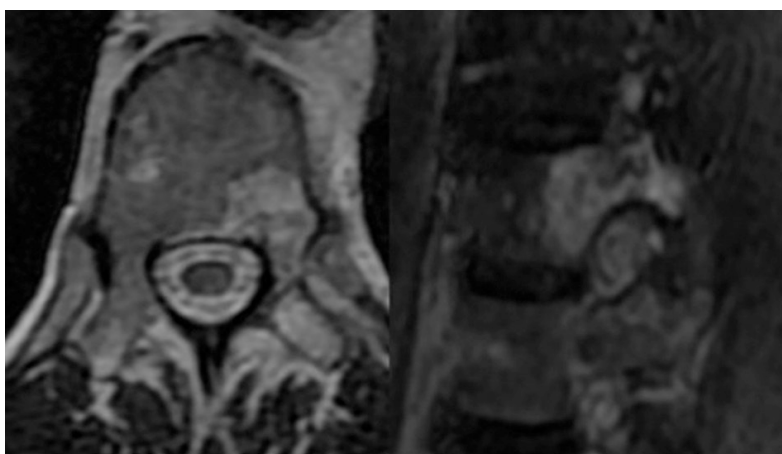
T2-weighted MRI of the 11th thoracic vertebra. Left pedicle: transverse process and the posterior half of the vertebral body presents hyperintensity signal interpreted as atypical hemangioma. The nerve root inside the foramen appears increased in volume.
